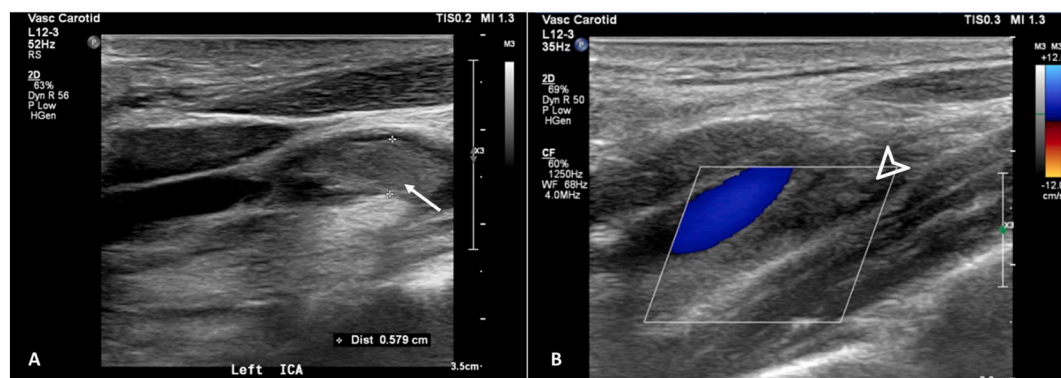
Carotid doppler ultrasound displaying intraluminal echogenicity within the proximal ICA (arrow) (A) and an absence of flow in the remaining ICA (arrow head) (B).
